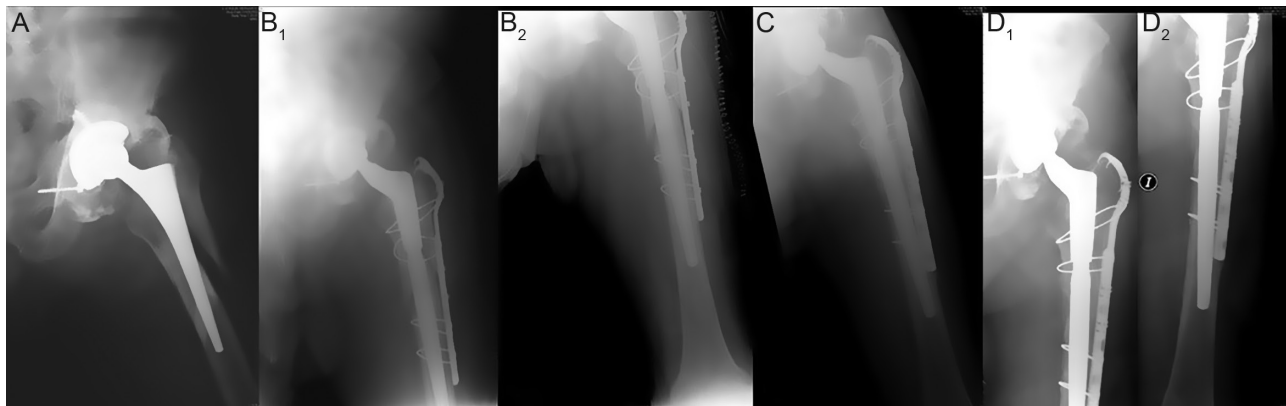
VB2 PPHF treated via RA. (A) VB2 PPHF; (B) postoperative control X-ray; (C) 1 year follow-up X-ray; (D) 2 years follow-up X-ray.
